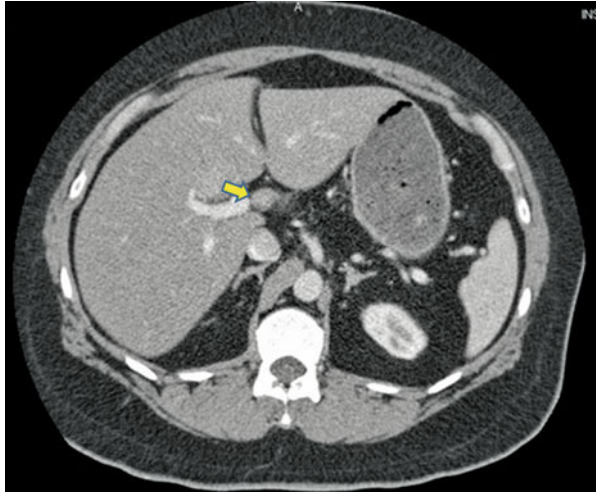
Axial CT image showing an intraparenchymal lymph node (*arrow*)
